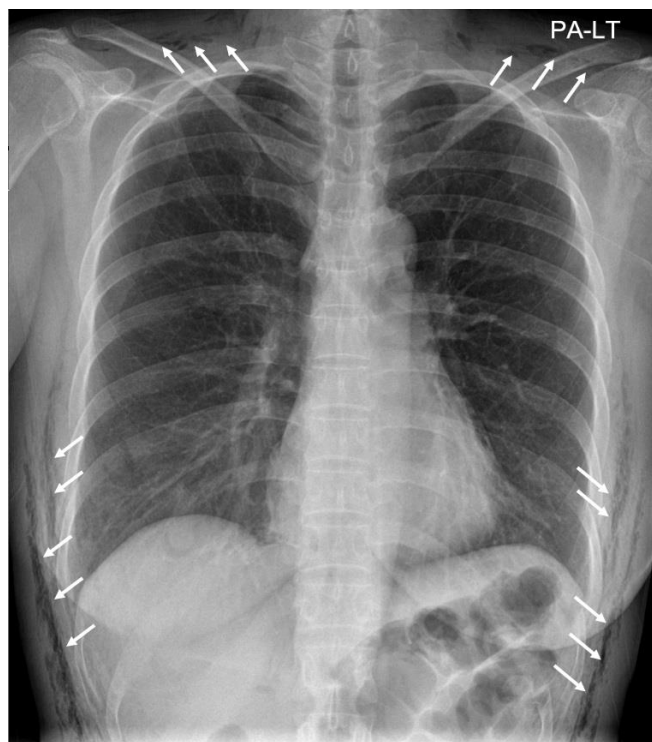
Postoperative chest radiograph (AP view) [white arrows show subcutaneous emphysema]
